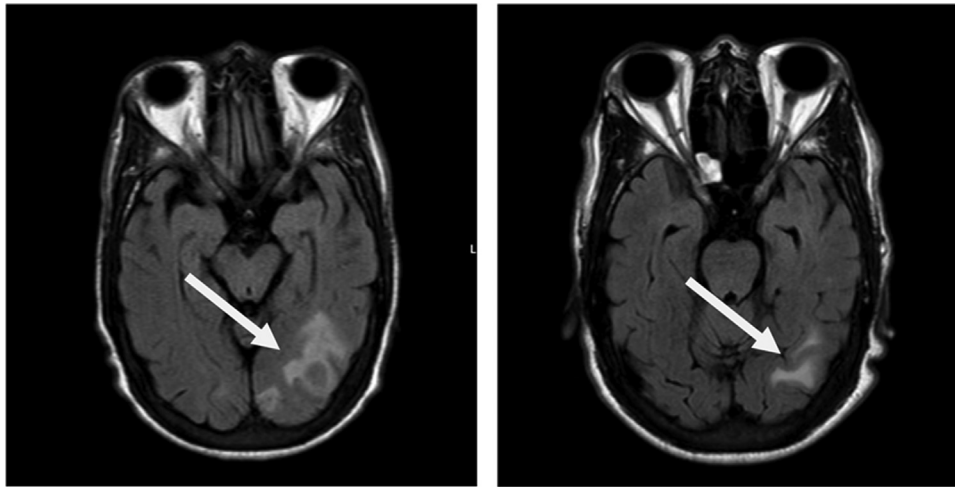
Patient 1, T2-weighted fluid-attenuated inversion recovery magnetic resonance imaging of the brain from before (left) and after 2 months of induction antibiotic therapy (right) for *Nocardia pneumoniae* (solid arrows).
